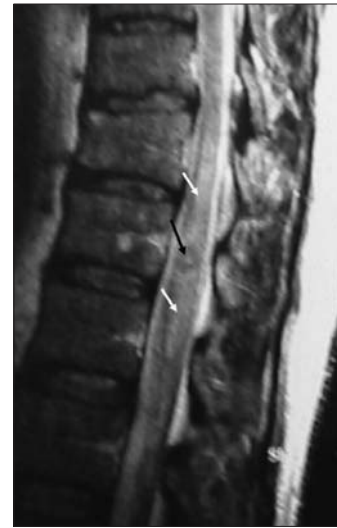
Sagittal T2-weighted MR image shows focus of hyperintensity (black arrow) within the hypointense lesion and perilesional edema (white arrows). Spinal cord appears slightly enlarged at T12 level.
